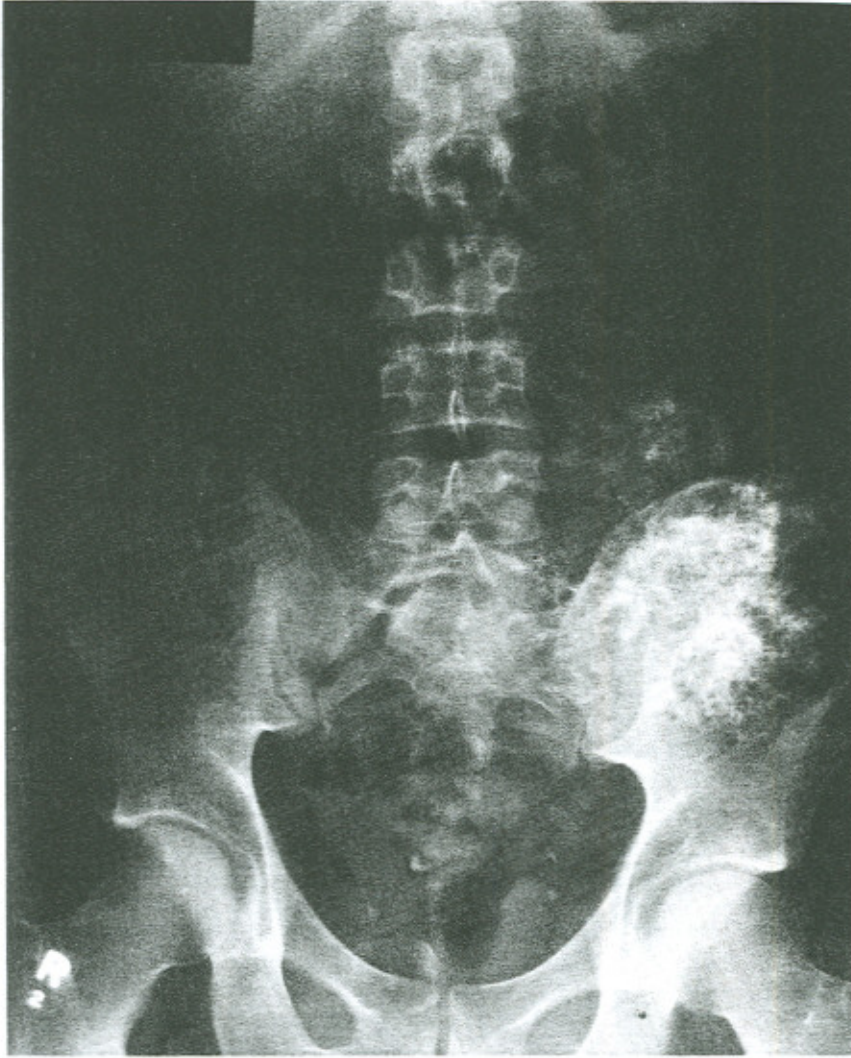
A pelvic radiograph shows a 15 × 15 cm mass in the left iliac fossa with mottled calcification, characteristic of a cartilage-based tumour. There is an increased amount of gas in the colon.
